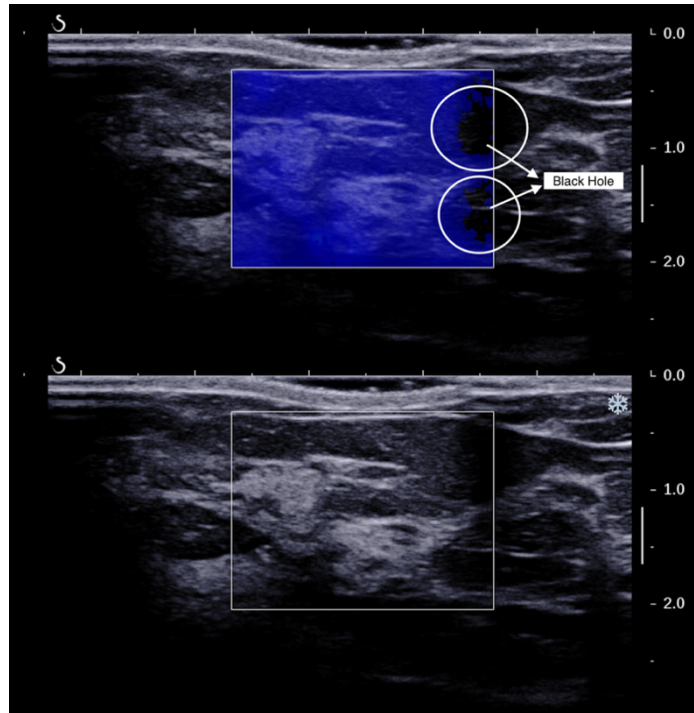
A Shear Wave ultrasound image with a black hole present
